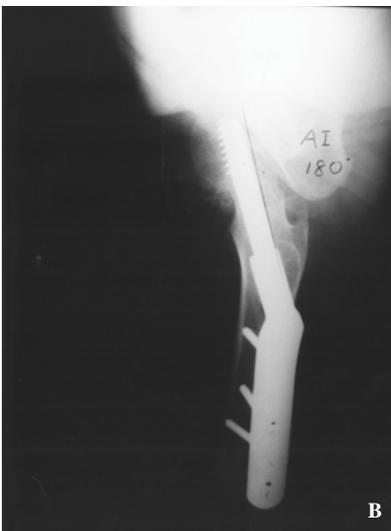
Postoperative hip anteroposterior radiograph of the left hip shows well reduced femoral neck fracture.
